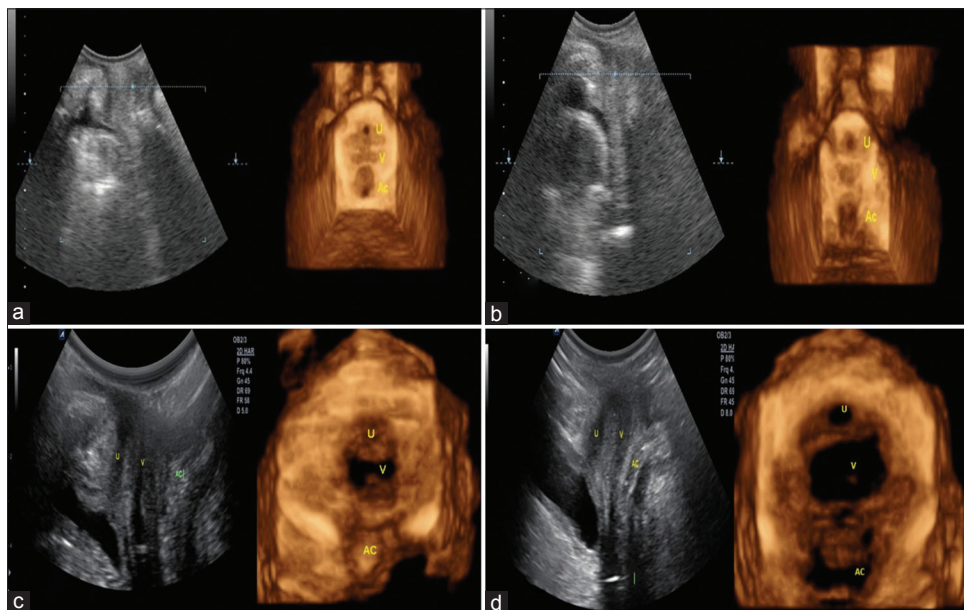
Ultrasonography features of normal vagina and neovagina. (a) Two-/three-dimensional images of sexually inactive normal vagina. (b) Two-/three-dimensional images of sexually active normal vagina. (c) Two-/three-dimensional image of neovagina in a sexually inactive vaginoplasty patient at 9 months postoperative period. (d) Two-/three-dimensional image of neovagina in a sexually active vaginoplasty patient at 9-month postoperative period
